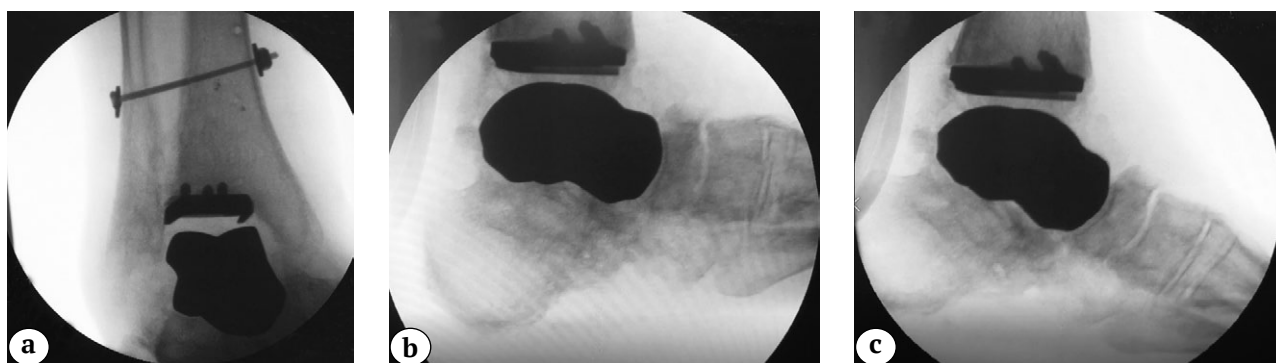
Control X-rays of the ankle joint 20 months after surgery: a – AP plane, good position of hardware is noted, preservation of the ankle contours; b, c – functional X-rays in the lateral plane of the plantar and dorsal flexion: good position of the endoprosthesis components is noted, total ROM is 28°
